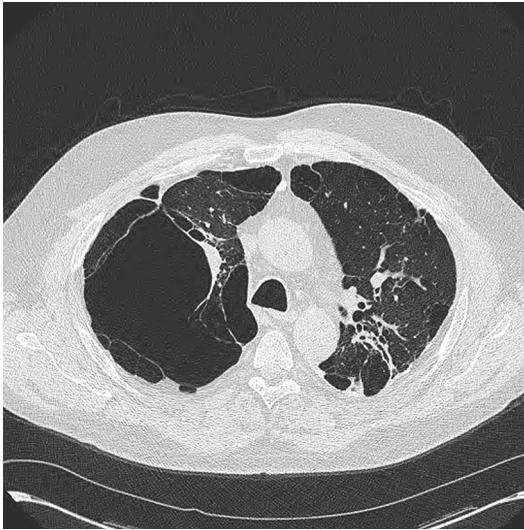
High-resolution CT scan demonstrating emphysematous as well as fibrotic changes in a patient with chronic sarcoidosis and pulmonary hypertension.
